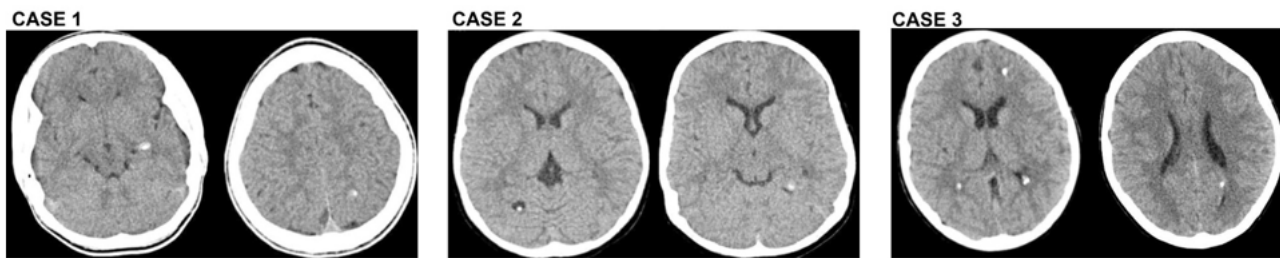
Non-Contrast Computed Tomography of the brain in three children presenting with seizures, headaches, and neurological signs. Case 1: Calcified lesions in the left insular region and left occipital lobes. Case 2: cystic lesion in the right occipital region with eccentric scolex at the granular stage, other calcified lesion in the left occipital lobes with surrounding edema, plus another cystic lesion anteriorly. Case 3: Calcifications of the choroid plexus, several calcified NCC, and active cystic lesions in the left parietal lobe one of them with mild perilesional edema.
